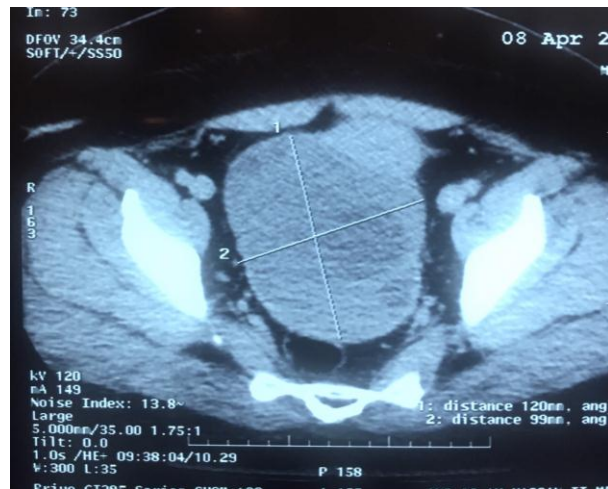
Pelvic CT scan in axial section: a massive solid-cystic mass 13 cm long axis, containing thick walls, with partially calcified peripheral fatty components, evoking an ovarian tumor.
